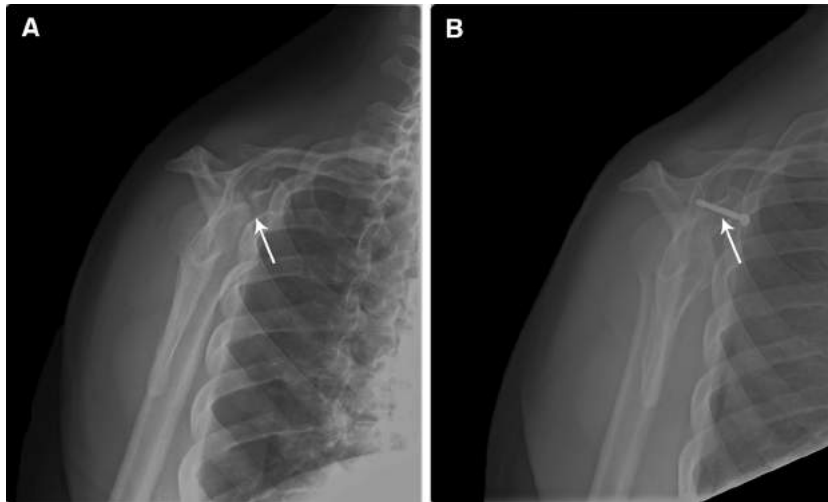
Radiographs showing the nonunion site (A, arrow) before operation and the healed nonunion site (B, arrow) with the screw at 6 months after operation.
